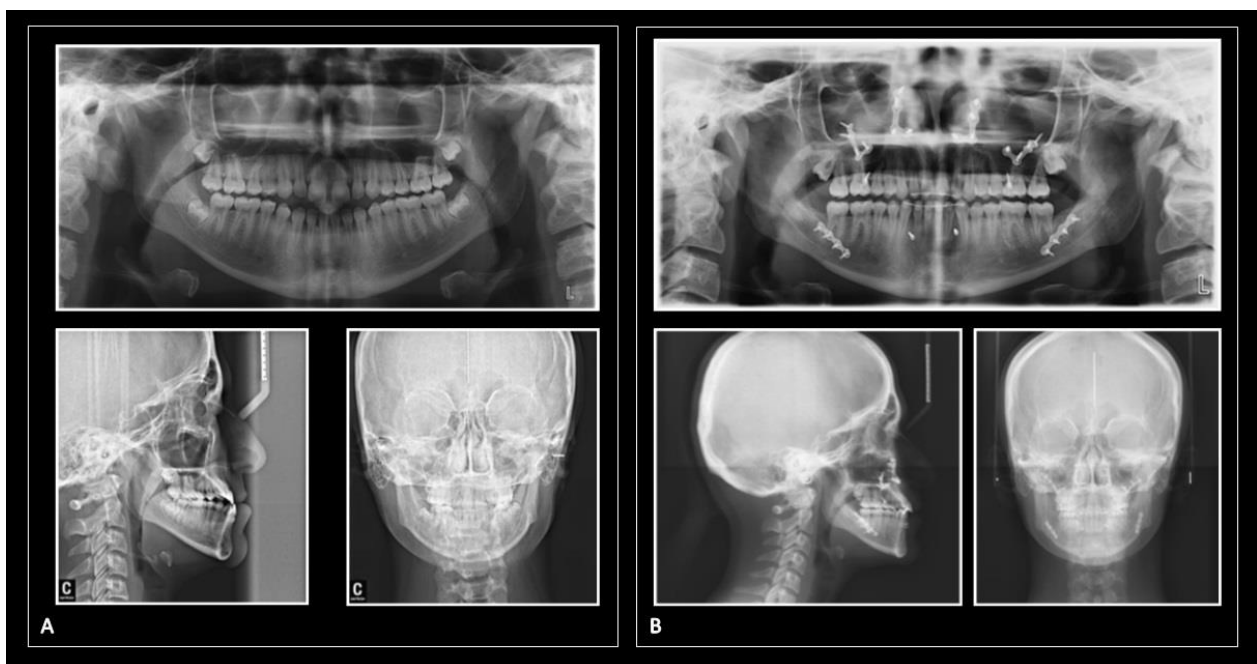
Pre- (A) and post-treatment (B) radiographs of Case 2.
